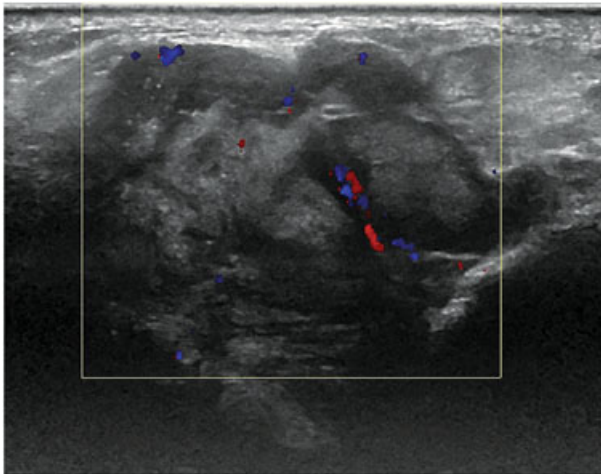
Colour Doppler demonstrates the lobulated mass contains internal vascularity.
